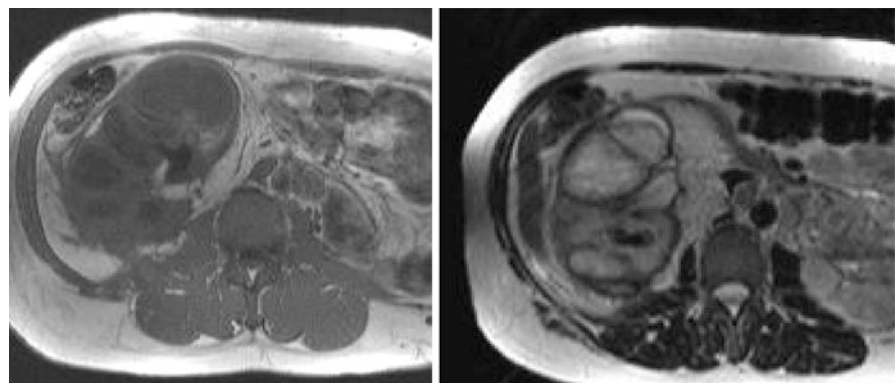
MRI of xanthogranulomatous pyelonephritis: Infection focus shows high signal intensity in T2 weighted MRI (*right*), while T1 sequence shows corresponding areas with low signal intensity
